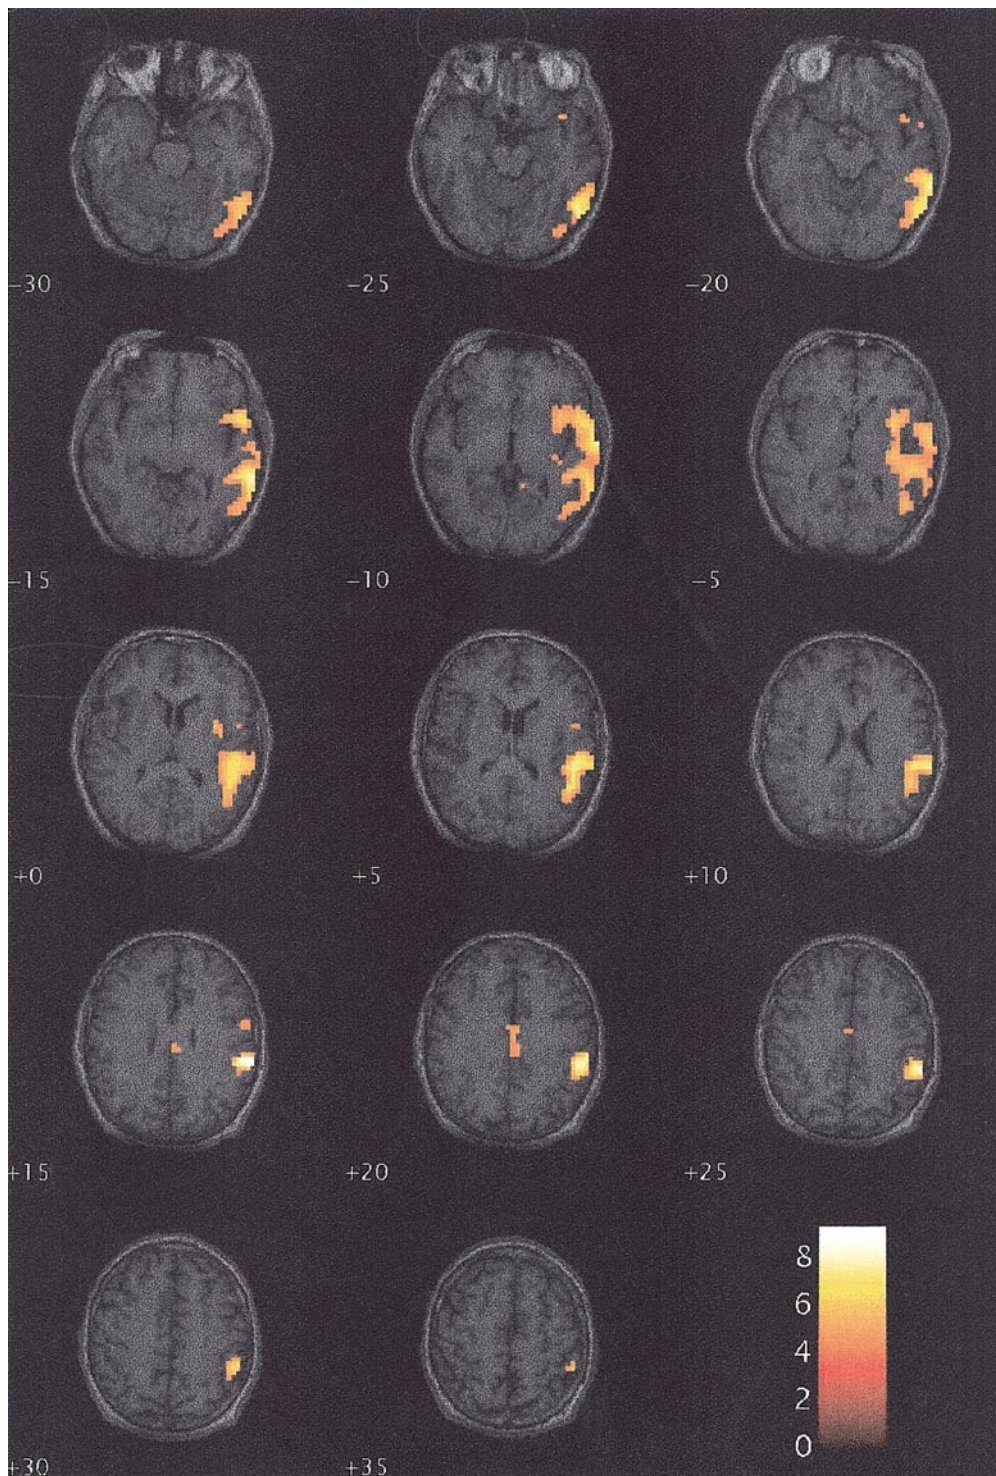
Anatomical overlay. The seizure related activation obtaining from Fig. 2b is shown overlaid onto consecutive slices of a coregistered T1-weighted scan.
